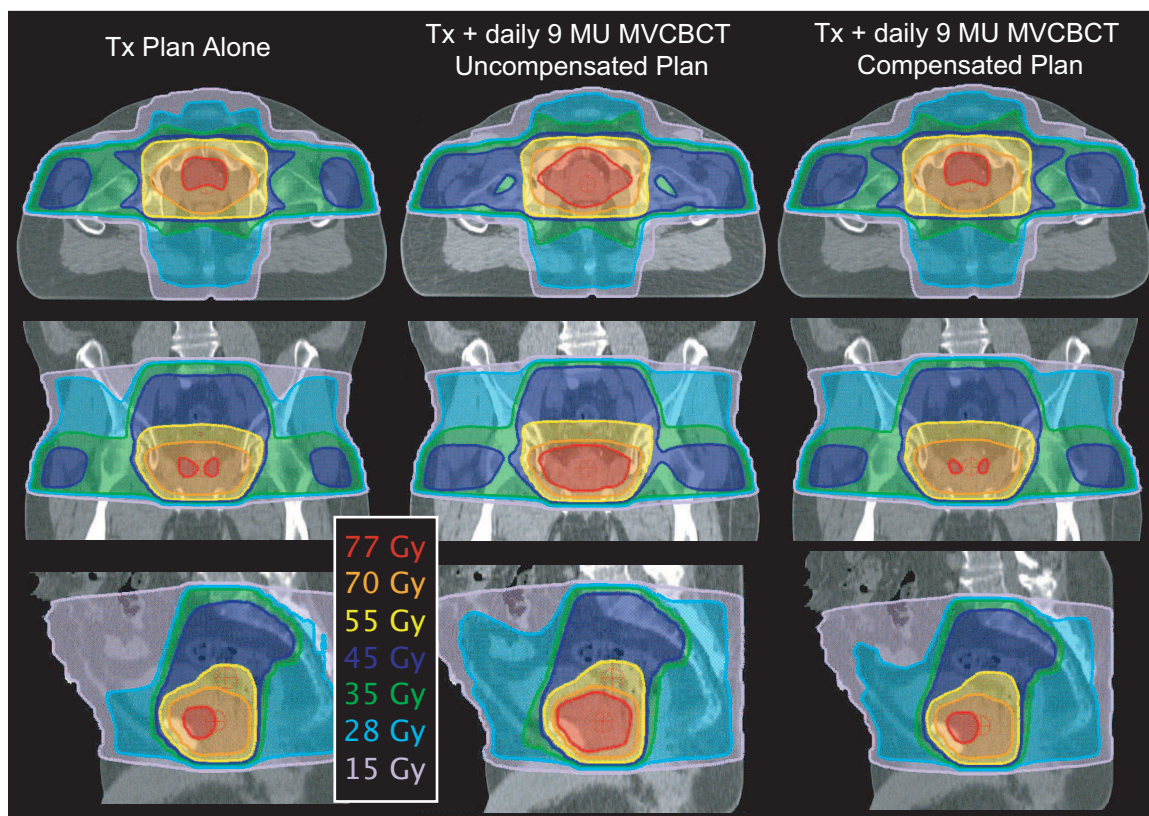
Dose distributions calculated on a pelvis patient for different plans combining treatment and MVCBCT imaging dose. This prostate patient was treated with a 4 field box (25 fractions) to the whole pelvis followed by two boosts; the first one including seminal vesicles and prostate (5 fractions), and the second including only the prostate (10 fractions). The treatment plan alone (treatment dose alone) (left) is compared with an uncompensated plan (treatment dose +  $40 \times 9$  MU MVCBCT) (middle) and a compensated plan (96% treatment dose +  $40 \times 9$  MU MVCBCT) (right).
